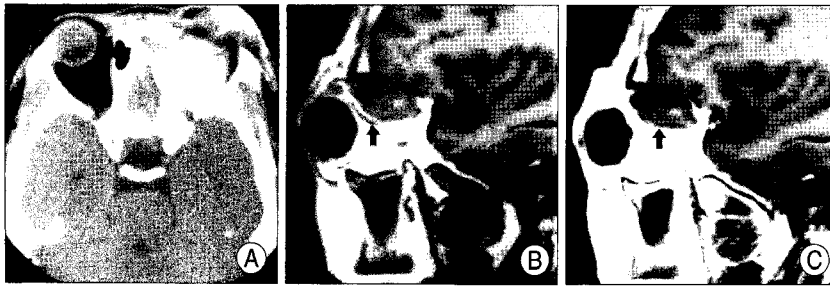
Preoperative findings of the orbital computed tomography (CT) and magnetic resonance image. A : Orbital CT revealed high density mass in the upper part of the left orbital cavity. B : On T1-weighted sagittal image, superior orbital muscular structures are compressed by inhomogenous signal intensity mass with elliptical margin. C : On Gd-enhanced sagittal image, the crescent shaped margin of the mass is enhanced inhomogeneously (arrow).
